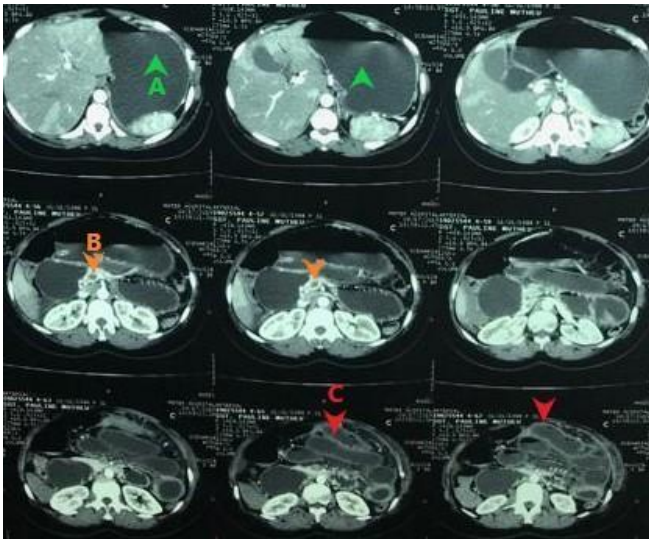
Computed tomography angiographic images of the abdomen showing salient features of superior mesenteric venous thrombosis. (A) Green arrows showing distended fluid-filled stomach. (B) Orange arrows showing filling defect in SMV. (C) Red arrows showing dilated and thick-walled jejunal loops
